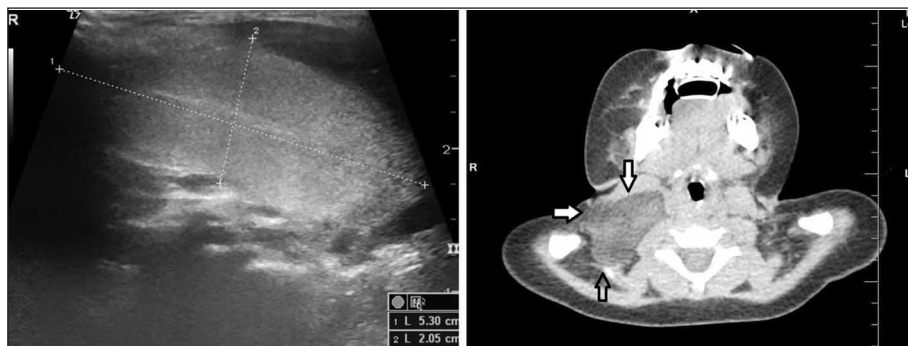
The preoperative work-up that demonstrates the lesion on the right side of the neck by ultrasonography on the right and computerized tomography on the left.
